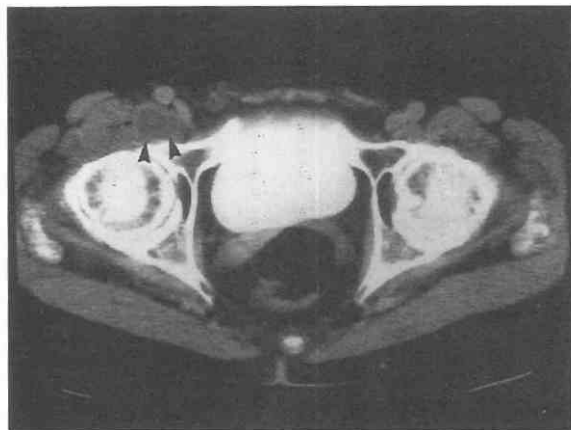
CT scan shows an iliopsoas bursal fluid collection (arrowheads) with a higher-attenuation fibrous wall (arrows) resulting from iliopsoas bursitis.
